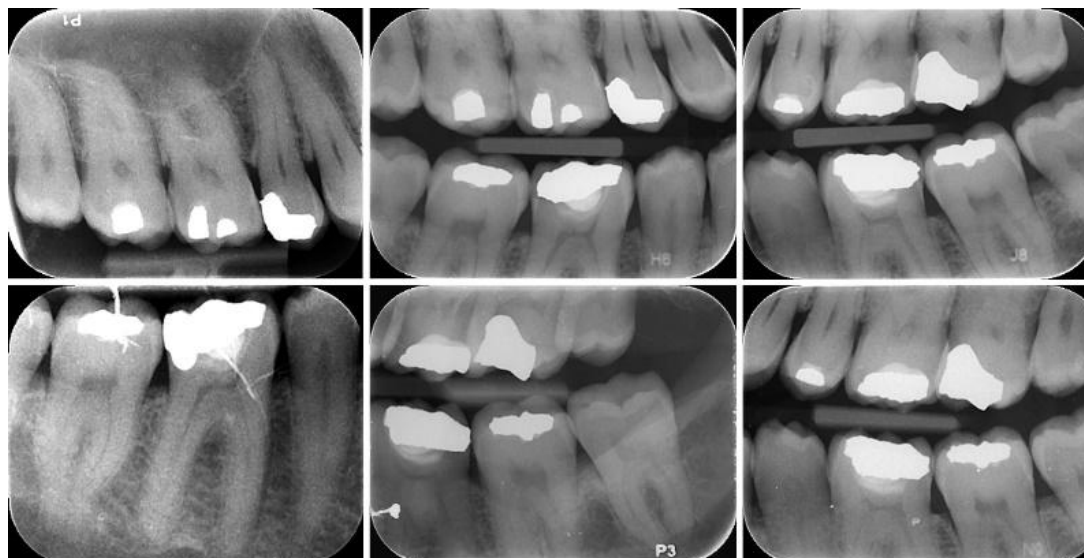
Intraoral radiographs demonstrated the presence of restorative fillings in the teeth with no radiographic evidence of dental sepsis.
